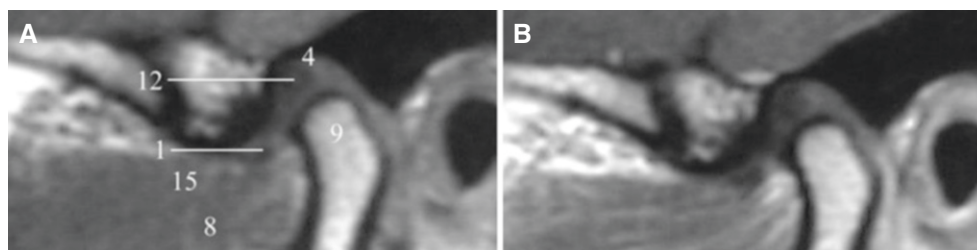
Normal bone and disc anatomy, asymptomatic volunteer; i.v. injection of contrast medium. (A) Oblique sagittal T1-weighted pre-Gd and (B) oblique sagittal T1-weighted post-Gd MRI show no or minimal contrast enhancement
